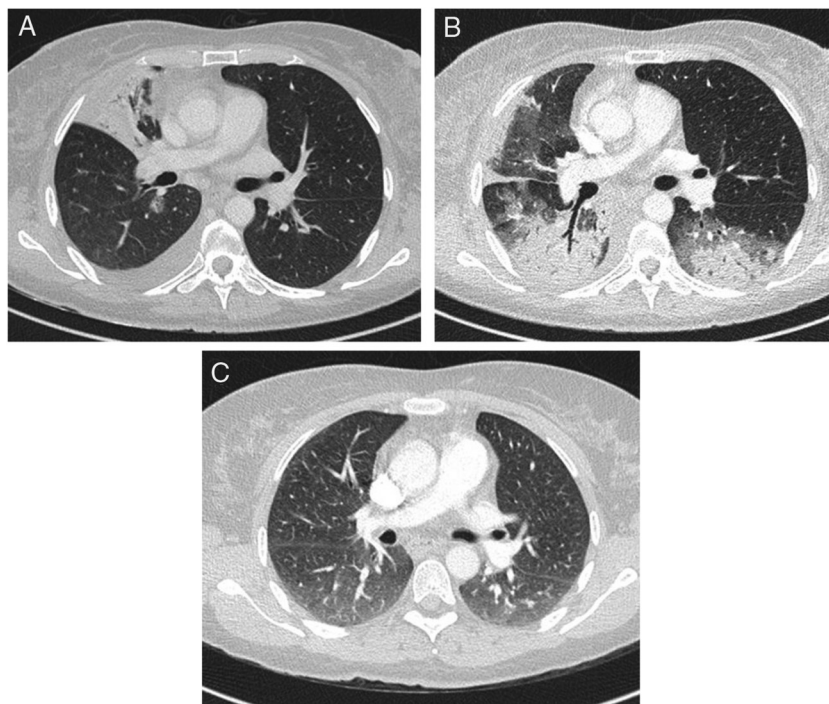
Chest CT of patient 1: (A) day 0: consolidation in lower right lobe; (B) day 12: ground glass opacities plus consolidations in bilateral upper lobes; (C) day 110: almost complete resolution of consolidations.
